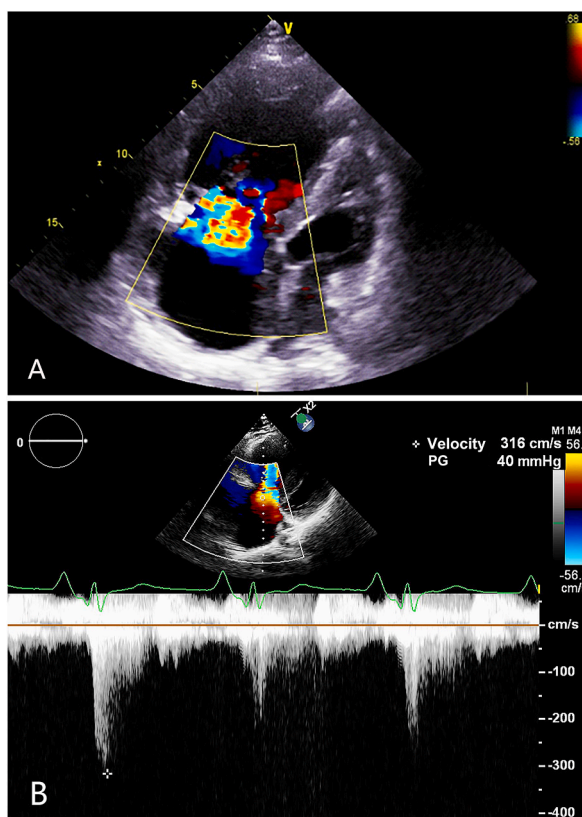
Follow-up echocardiography in 2021. Despite the presence of severe tricuspid regurgitation (A), the estimated pulmonary artery systolic pressure was measured at 55 mm Hg (B).
